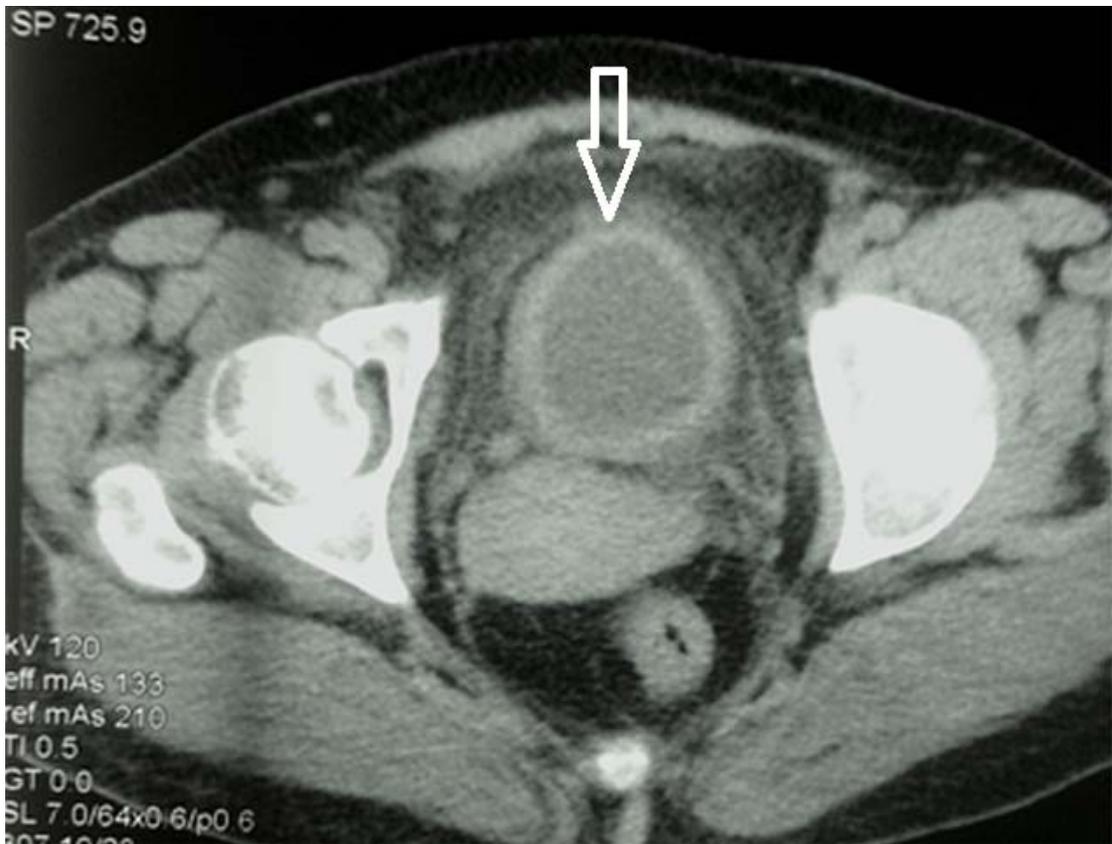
Computed tomography (CT) scan showing a thick bladder wall with significant fat stranding around the bladder (arrow)
